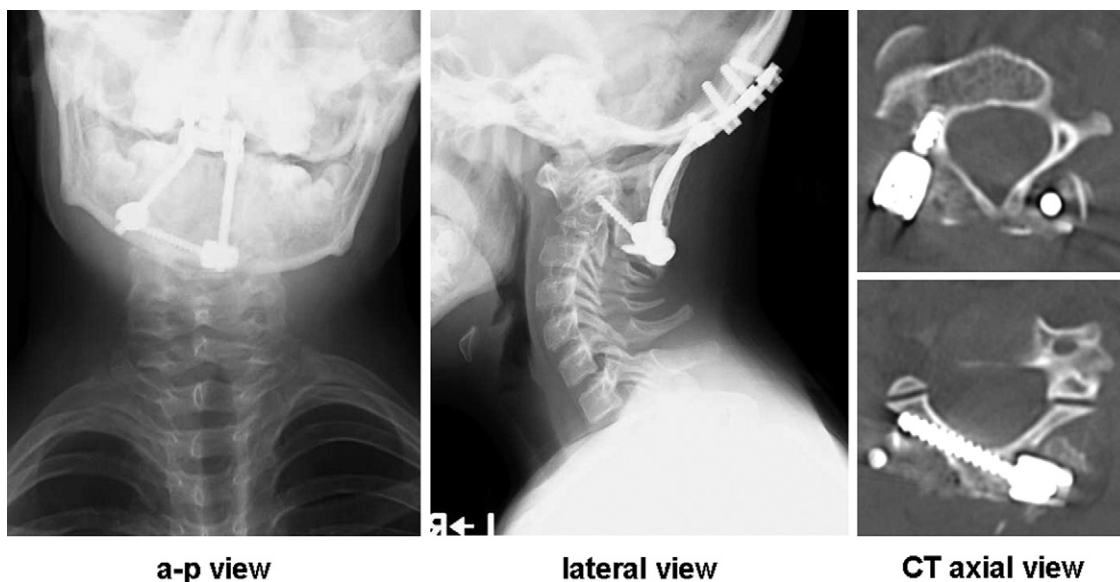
Postoperative X-ray (obtained 1 year 6 months after surgery) and CT scan (obtained 1 week after surgery) in case 2. Alignment of the cervical spine had improved, and the accurate insertion of both right C2 pedicle and left C2 laminar screws was confirmed. (a-p, anteroposterior.)
